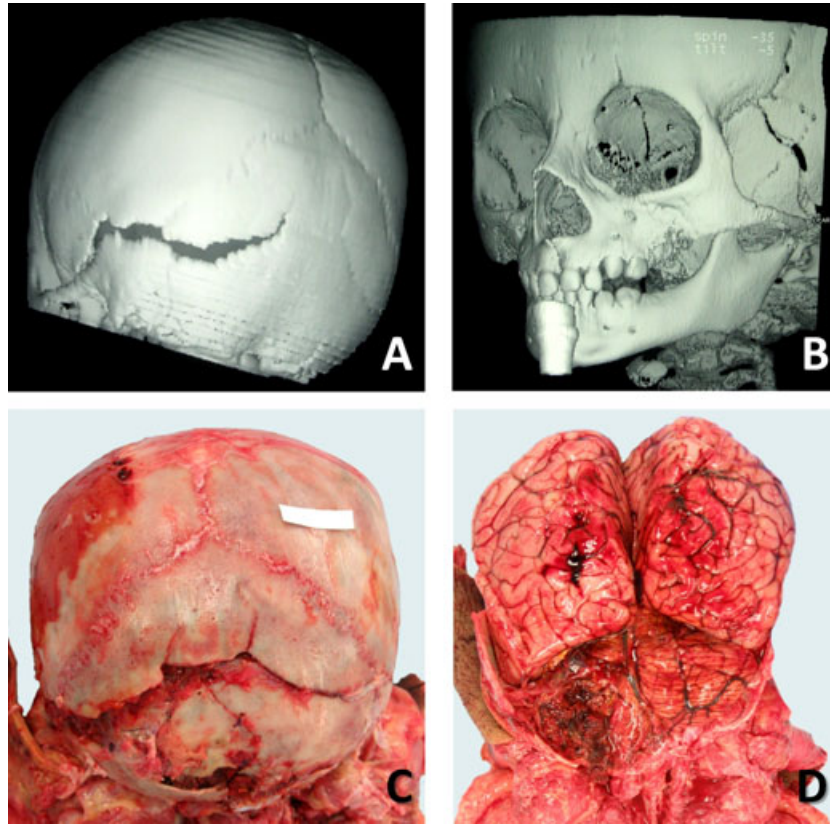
Patient 1. (A, B) Three-dimensional reconstructions of the admission CT scans demonstrating a gaping fracture extending anterolaterally from the left lateral aspect of the occipital bone across the temporal portion of the inferior parietal bone, squamous portion of the left temporal bone, and greater wing of the sphenoid bone, terminating at the left sphenofrontal suture. A simple linear fracture of the left frontal bone terminates after extending across the left orbital shelf. (C) Posterior aspect of the skull demonstrating the disruption of the preintervention injuries by postsurgical changes. (D) Posterior view of the brain, in situ, demonstrating subarachnoid hemorrhage, cerebral edema, and disruption of the left cerebellar hemisphere.
